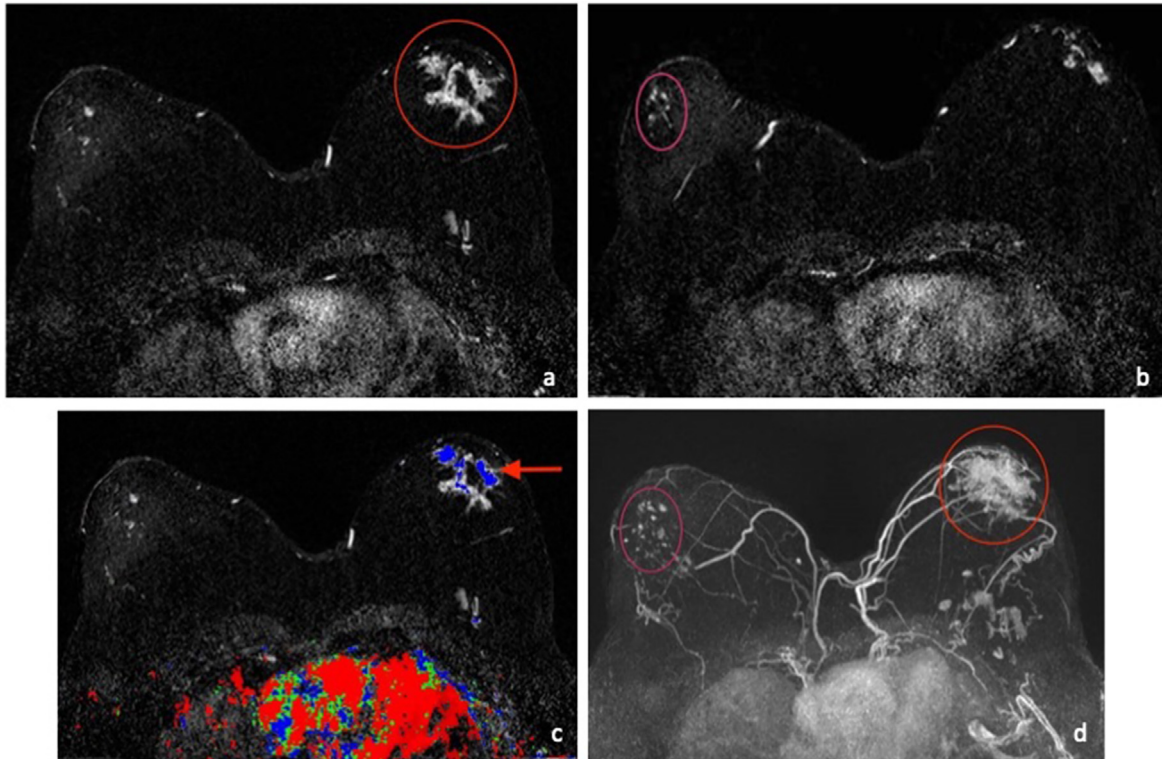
Magnetic resonance imaging of the breasts ([A and B] axial post contrast T1 subtraction images, [C] axial dynamic contrast enhanced T1 image with color, [D] axial post contrast maximum intensity projection image) demonstrated clumped non-mass enhancement (red circle), with plateau kinetics (red arrow), in the left retroareolar breast, measuring 7 × 7.1 × 6.2 cm. Additionally, in the right retroareolar breast, there was non-mass enhancement (pink circle) in a segmental distribution measuring 8.5 × 5.2 × 2.9 cm.
